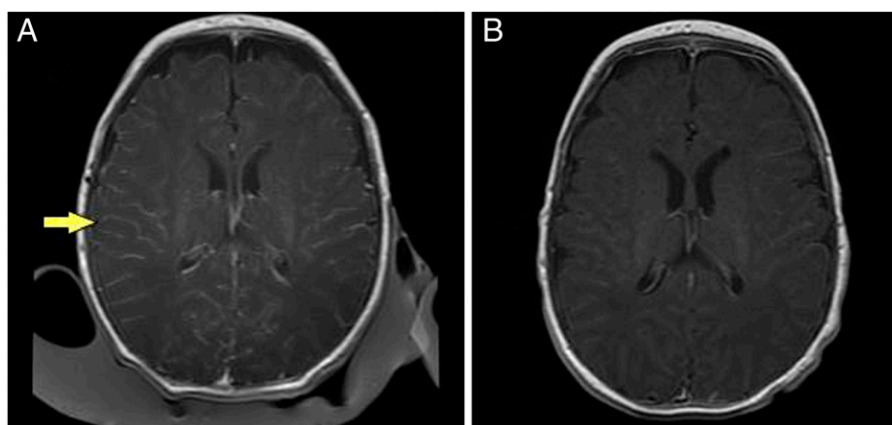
Magnetic resonance imaging of the brain. A. Leptomeningeal enhancement (yellow arrow) is seen after gadolinium administration. B. Enhancement disappears after treatment.
